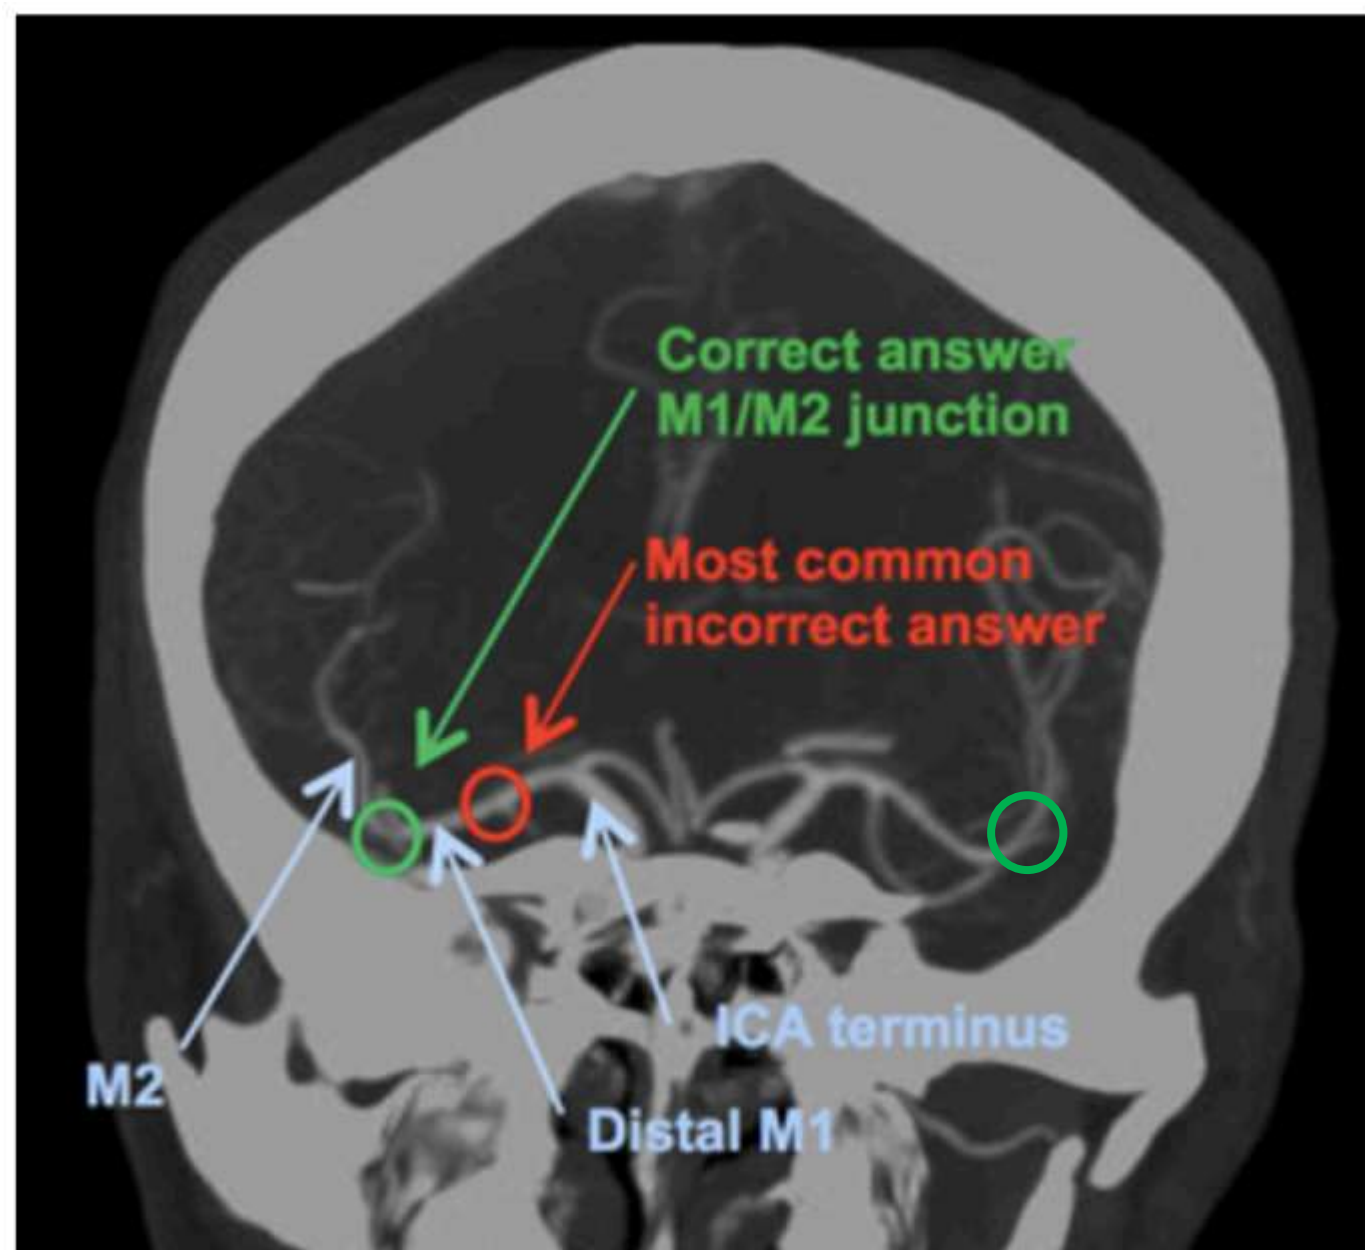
CT Angiogram coronal head MIP image with arrows showing relevant anatomy and most common answers. The horizontal M1 segment transitions to M2 as it enters the Sylvian fissure, then it curves upwards (MCA genu)
